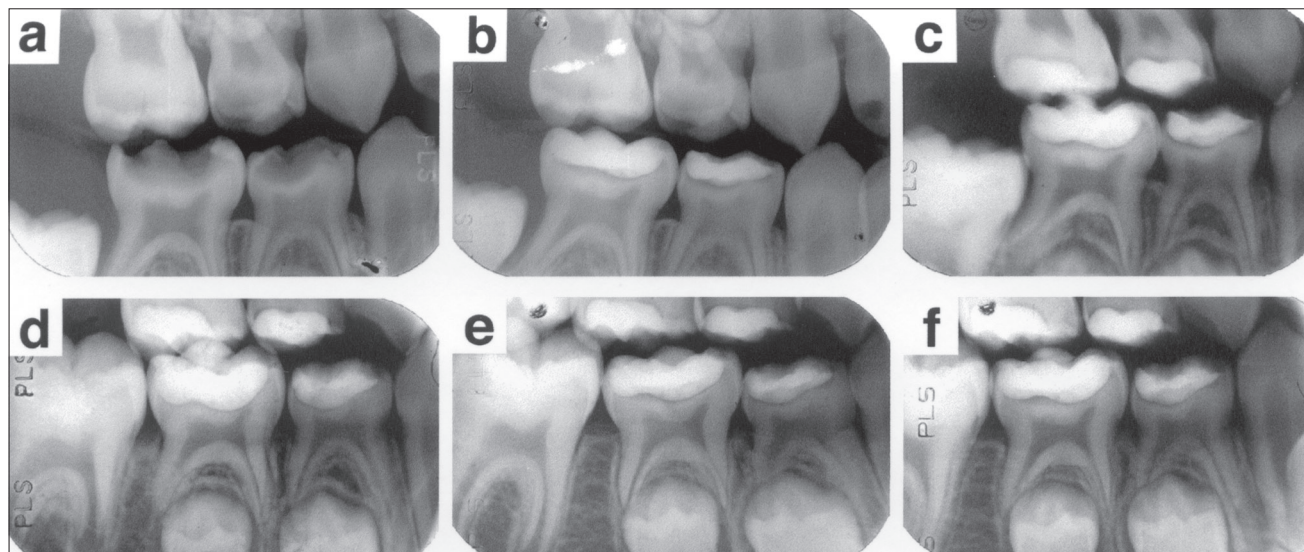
Radiographic evaluation of a mandibular first and second primary molar that received indirect pulp treatment with adhesive resin only and were considered successful outcomes after 2 years. Preoperative radiograph (a), immediate postoperative (b), and 6 months (c), 12 months (d), 18 months (e) and 24 months (f) after indirect pulp treatment.
